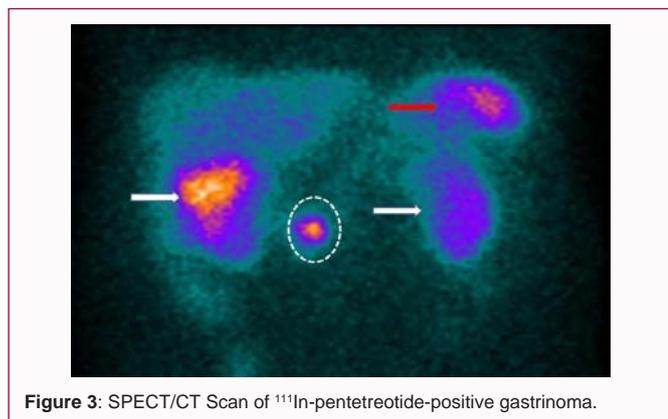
SPECT/CT Scan of ^{111}In -pentetreotide-positive gastrinoma.
